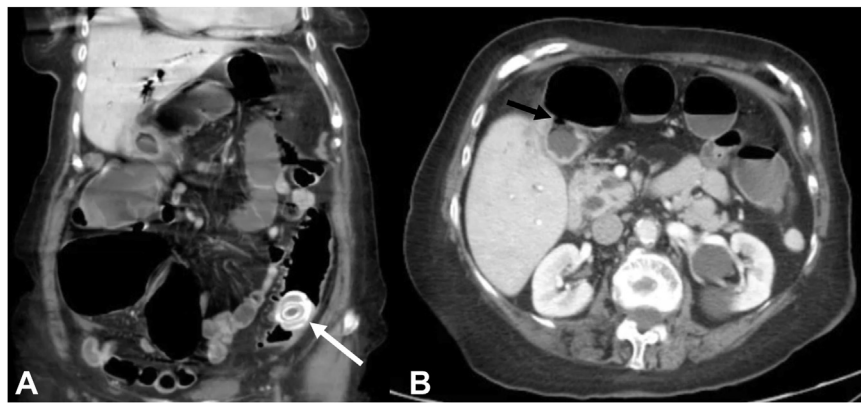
Coronal cut of abdominal CT scan showing the impacted gallstone in the sigmoid colon (*white arrow, A*). Axial cut of abdominal CT scan that demonstrates cholecystocolonic fistula (*black arrow*) and dilated bowel loops with presence of fluid levels (B).
